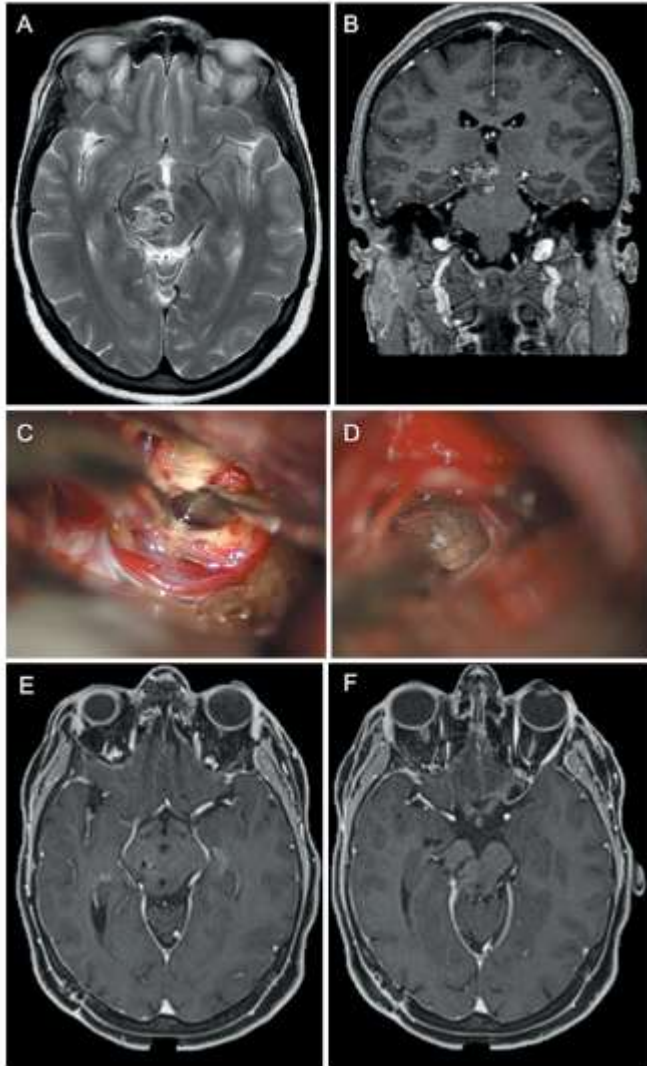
Case 3. Preoperative axial (A) and coronal (B) T2-weighted MR images showing a brainstem cavernoma at the level of the right cerebral peduncle. Intraoperative images showing the surgical access through the lateral mesencephalic sulcus (C) and the dyschromic area corresponding to the cavernoma (D) inside the brainstem. Postoperative axial T1-weighted MR images with gadolinium enhancement show in more caudal (E) and more cranial (F) sections the surgical entry point at the level of the right lateral mesencephalic sulcus and complete removal of the cavernoma.
